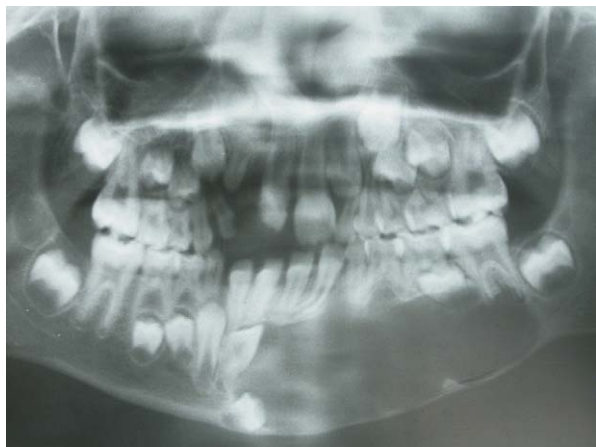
Dental panoramic radiography.
